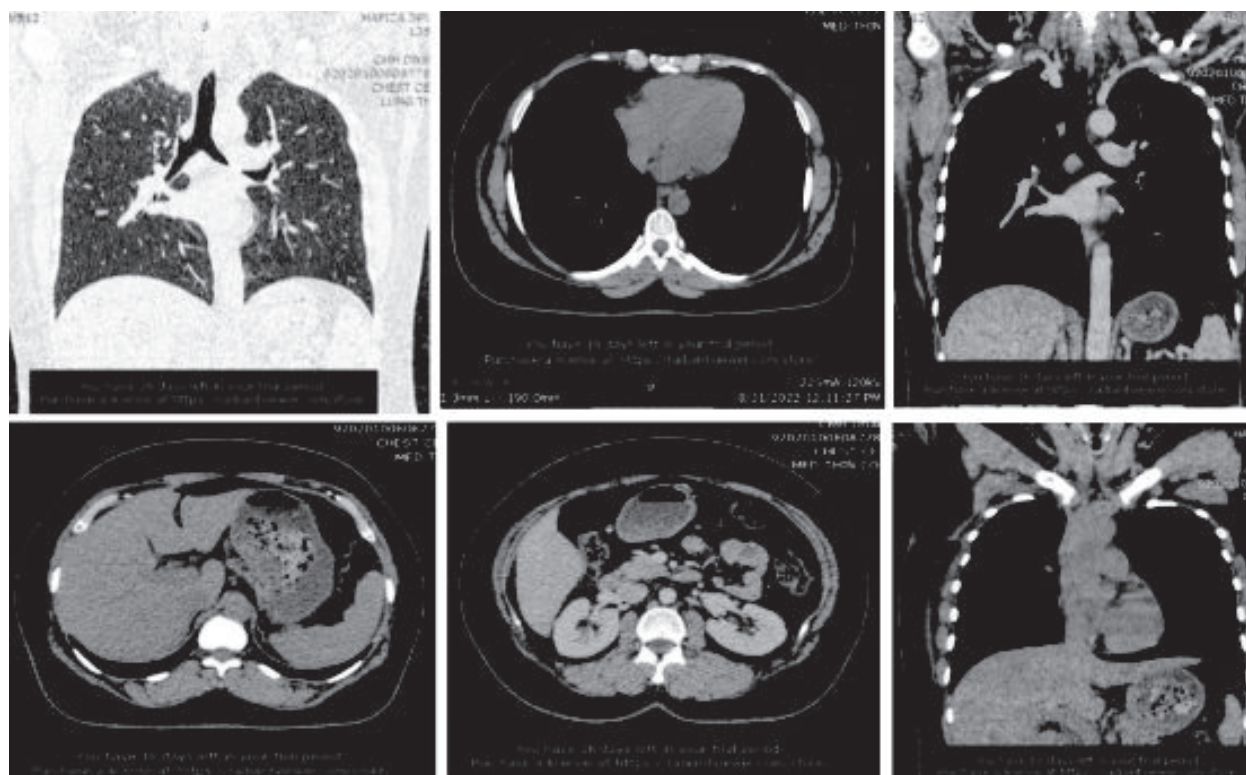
Non contrast axial and reformatted coronal CT scan of chest done on 31st august 2022 Multi axial images showed m0 metastasis, other features show no abnormality.(Fig-5)
